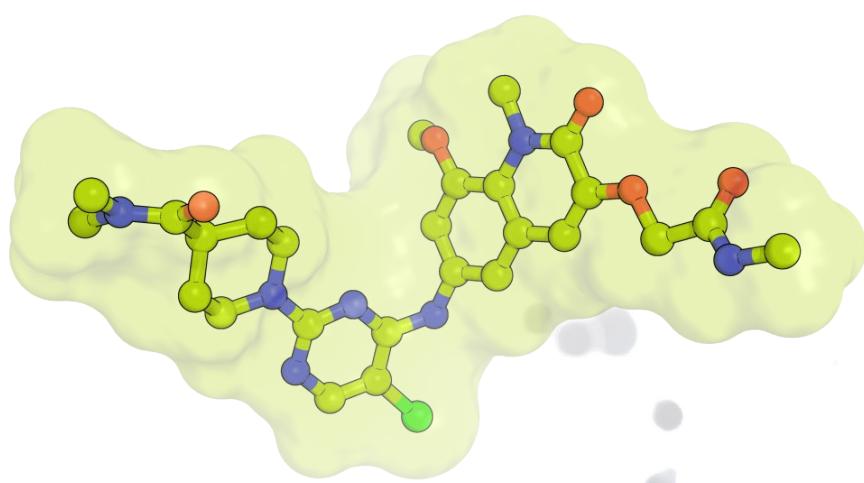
BI-3812, 3D conformation, based on X-ray structure with BI-3802
